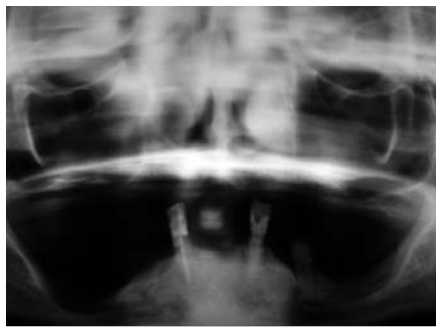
Radiograph of the patient's dentition on presentation.
